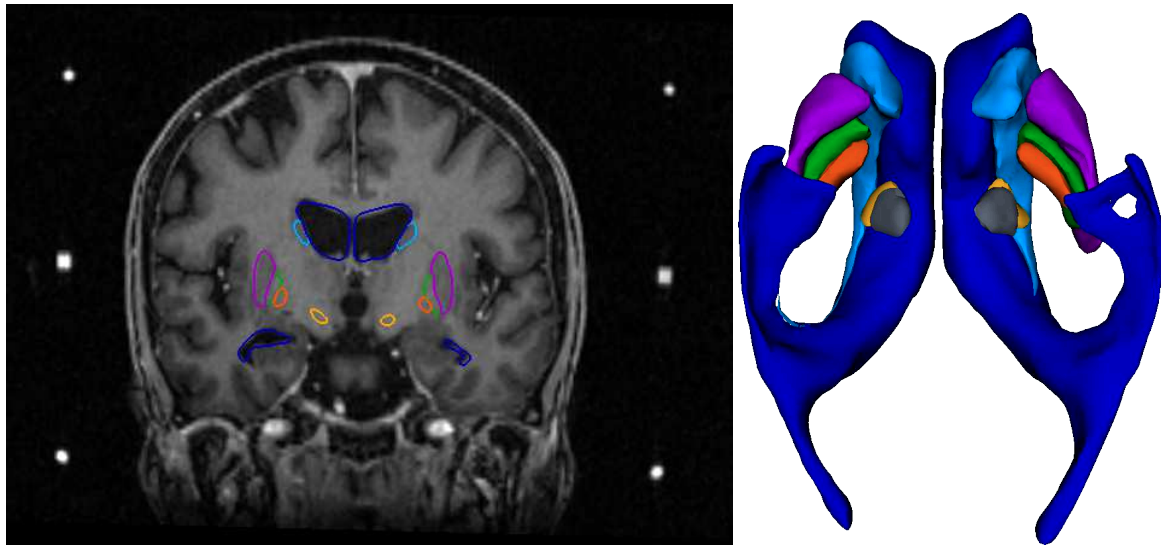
Basal Ganglia: MRI coronal view (left) and 3D view from the bottom (left).
